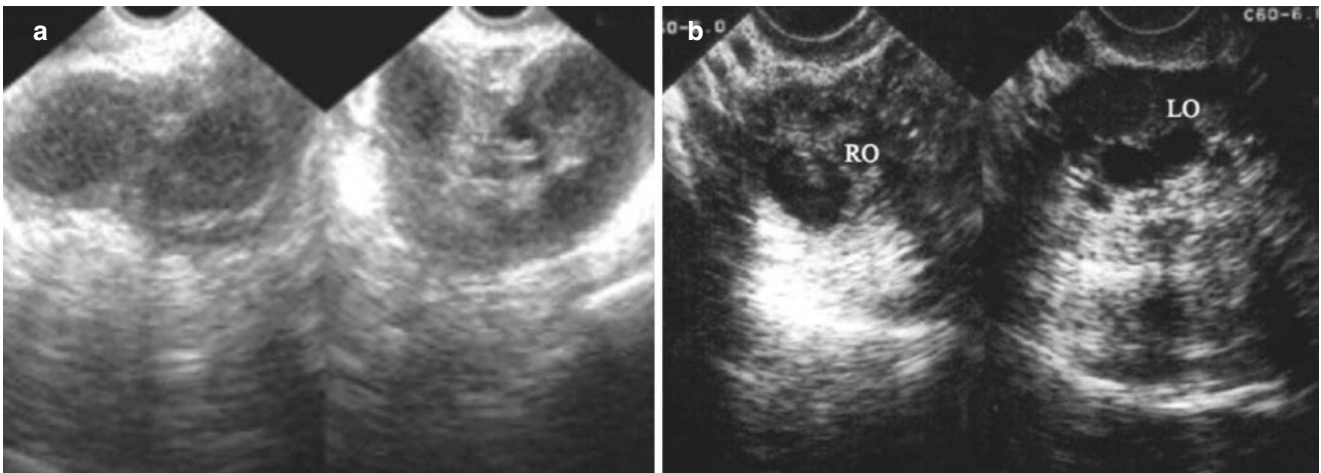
Adnexal inflammatory mass (II). (a) A 24-year-old patient represented lower abdominal pain for 1 week after contraceptive operation. The ultrasonic scanning shows a bilateral adnexal hypoechoic
